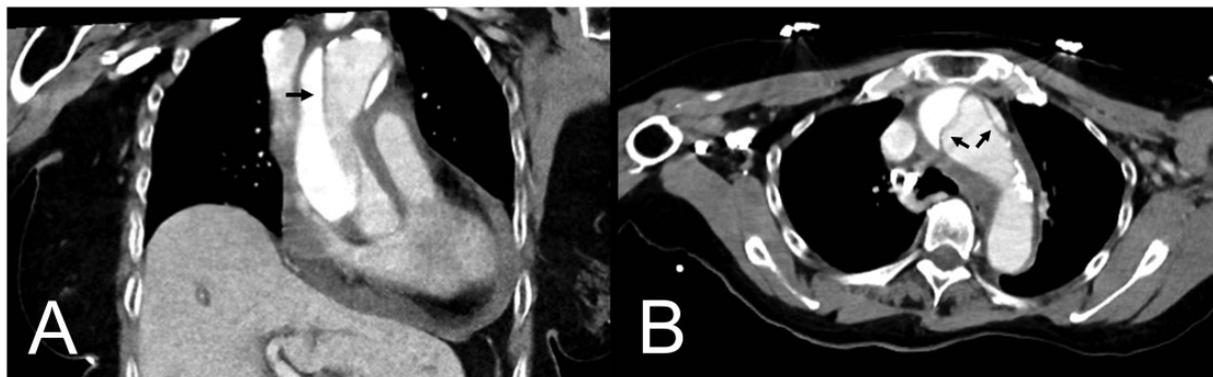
CT-angiography of patient No. 11, coronal (a) and transverse (b) planes. Arrows indicate Stanford classification type A acute aortic dissection.
